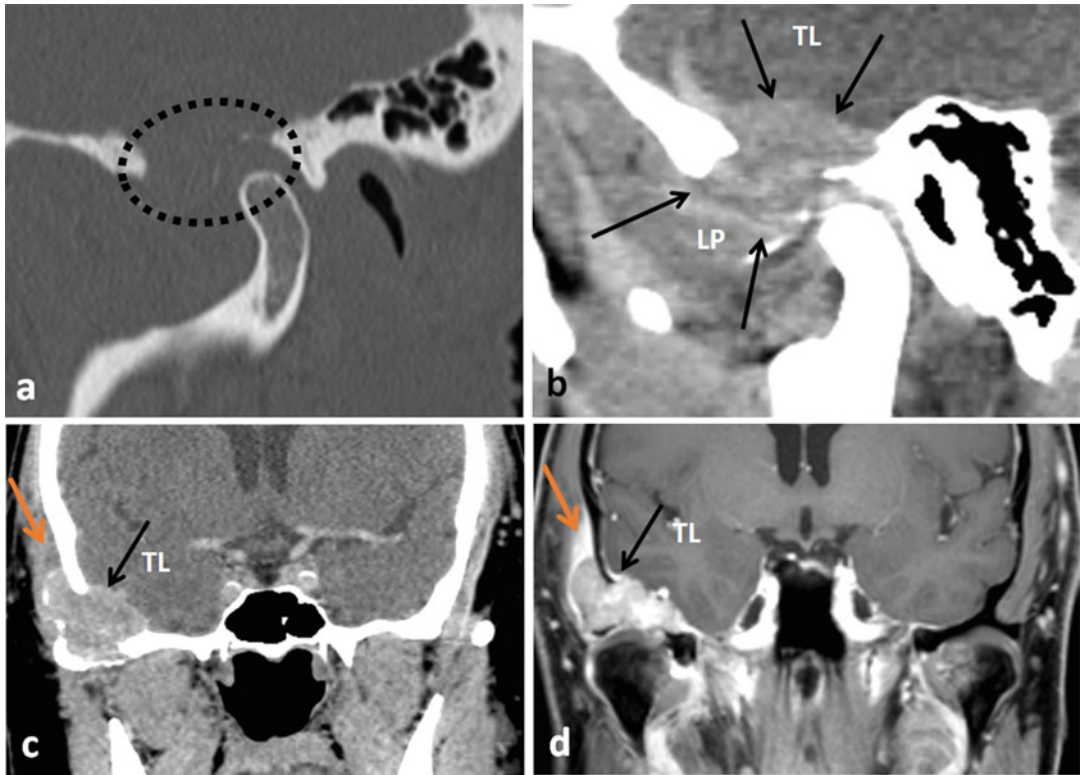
Chondroblastoma of the right articular eminence, glenoid fossa, and middle cranial fossa. Sagittal bone window CT reconstruction (a), sagittal post-contrast CT soft tissue reconstruction (b), coronal CT soft tissue reconstruction (c), and post-gadolinium, fat saturation, coronal T1-weighted MRI (d). There is a large enhancing mass (black arrows) destroying the articular eminence and glenoid fossa (black dotted oval in a) which extends
